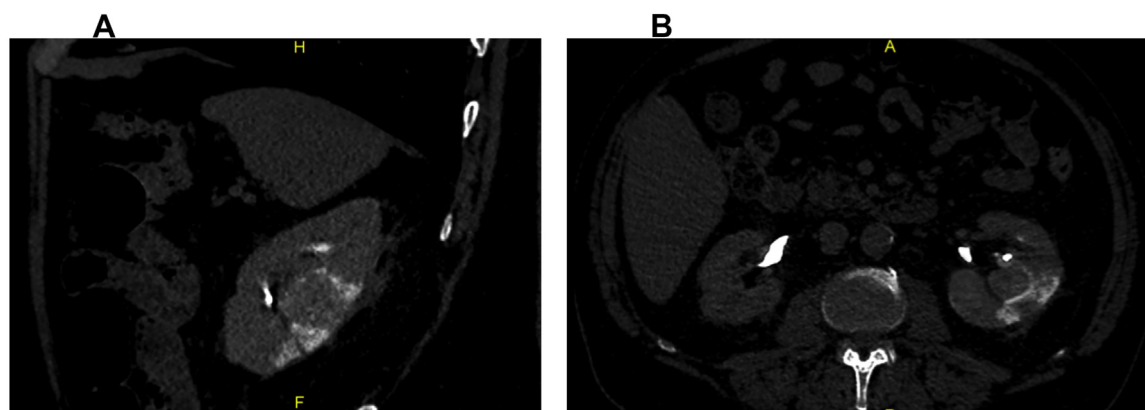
Immediate postangiographic CT scan to assess resection strategy based on estimated marked area. CT = computed tomography.
